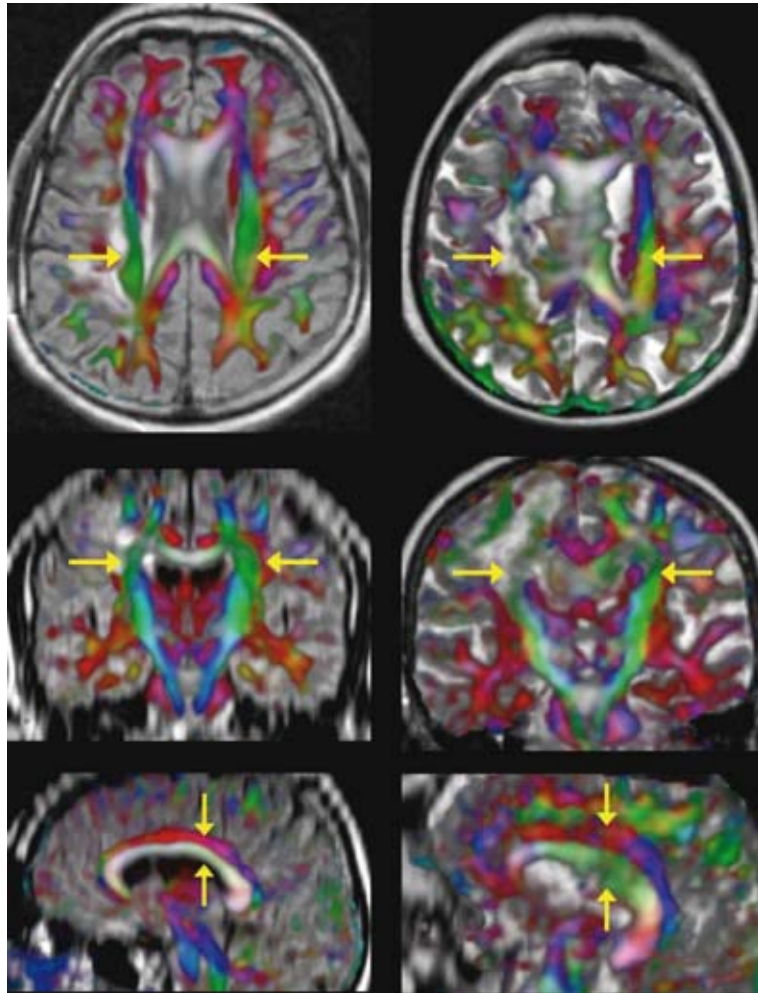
Axial, coronal and sagittal view of the anatomical MRI data with added DTI based color maps. Left: The (M, 47 y) patient without contralateral tumor progress. Right: The (F, 81 y) patient with contralateral tumor progress. In the sagittal view, for the patient with contralateral tumor progress, the partially reduced FA in the CC (arrows) indicates infiltration, while for the patient without contralateral tumor progress no significantly reduced FA can be observed (arrows). The FA inside the CC located directly above the CC is not significantly reduced for both patients (arrows). In the coronal and axial view, infiltration of the right PT can be observed for both patients by a, related to the left PT, reduced FA at the internal capsule (arrows).
